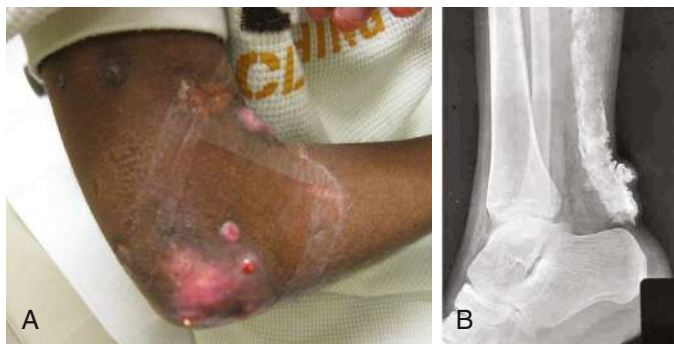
Calcifications in dermatomyositis. A, Skin effects of calcification. B, Radiographic evidence of calcification.
